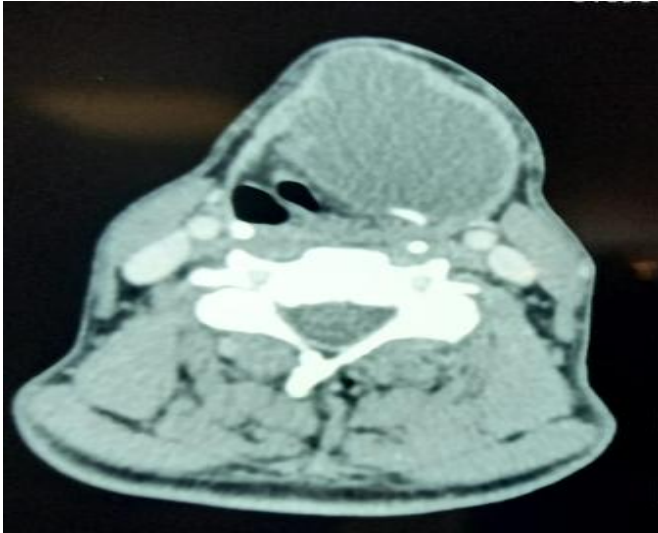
Axial CT scan image demonstrating a laryngomucocèle.
